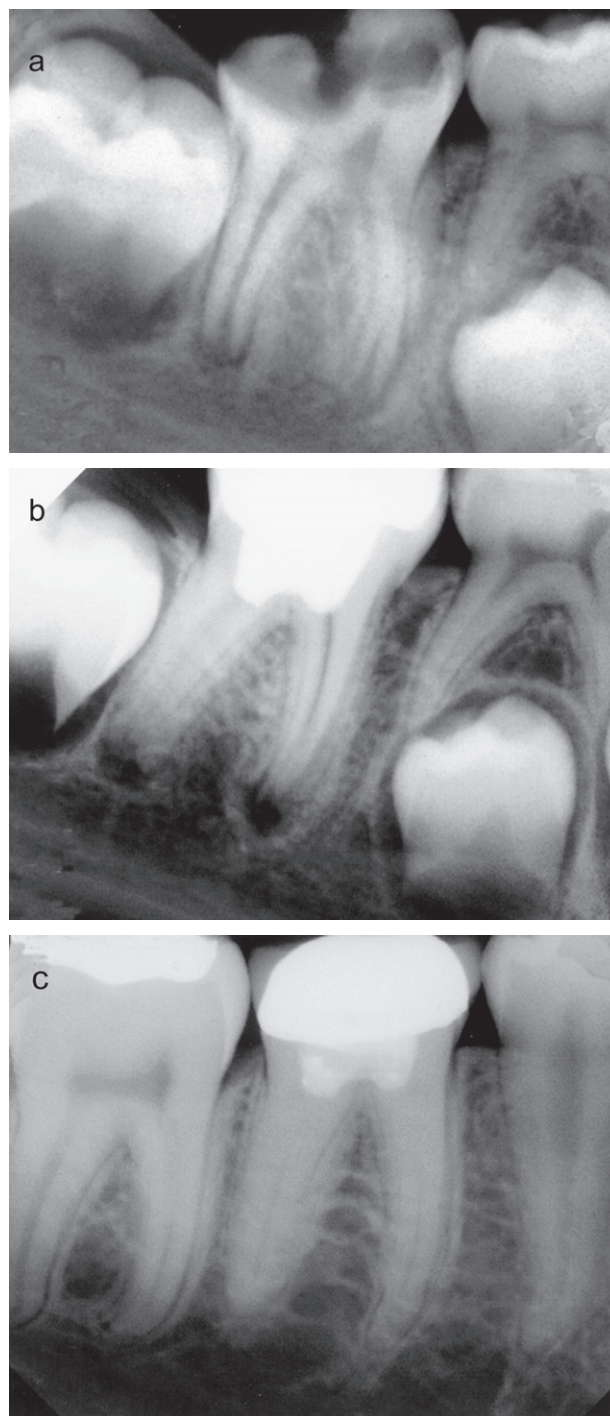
(a) Pre-operative radiograph of the right mandibular first molar shows the presence of extensive decay and open apices. (b) After removing the decay and performing a pulpotomy, the pulp stumps were covered with MTA and the tooth was restored with a permanent filling of amalgam. (c) A post-operative radiograph after 7 years shows normal periapical tissues and the closure of root canals with dentin. The tooth is asymptomatic and has been restored with a permanent crown. Courtesy of Dr. M. Lindemann.
